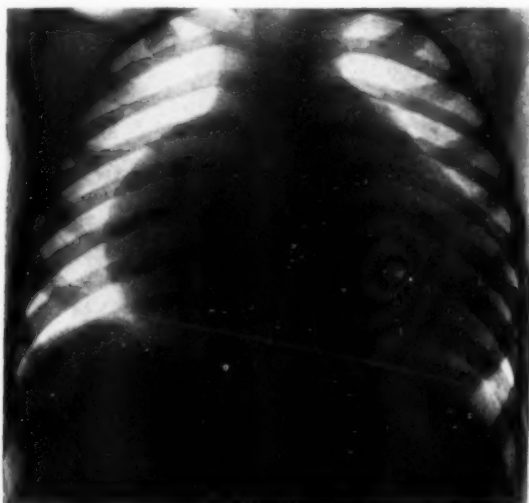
(Case 3).—Plain roentgenogram of chest reveals: globular heart; very large right auricle and (?) right ventricle; left pulmonary artery prominent, and lungs underfilled.
